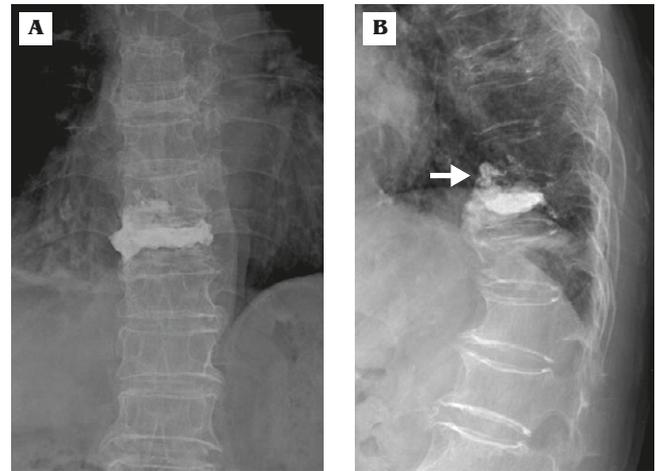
(A) Anteroposterior and (B) lateral plain radiography of the thoracolumbar spine taken in an outpatient follow-up show the injected cement in the T10 and T11 vertebrae with the cement joined in the right anterior area (arrow).
